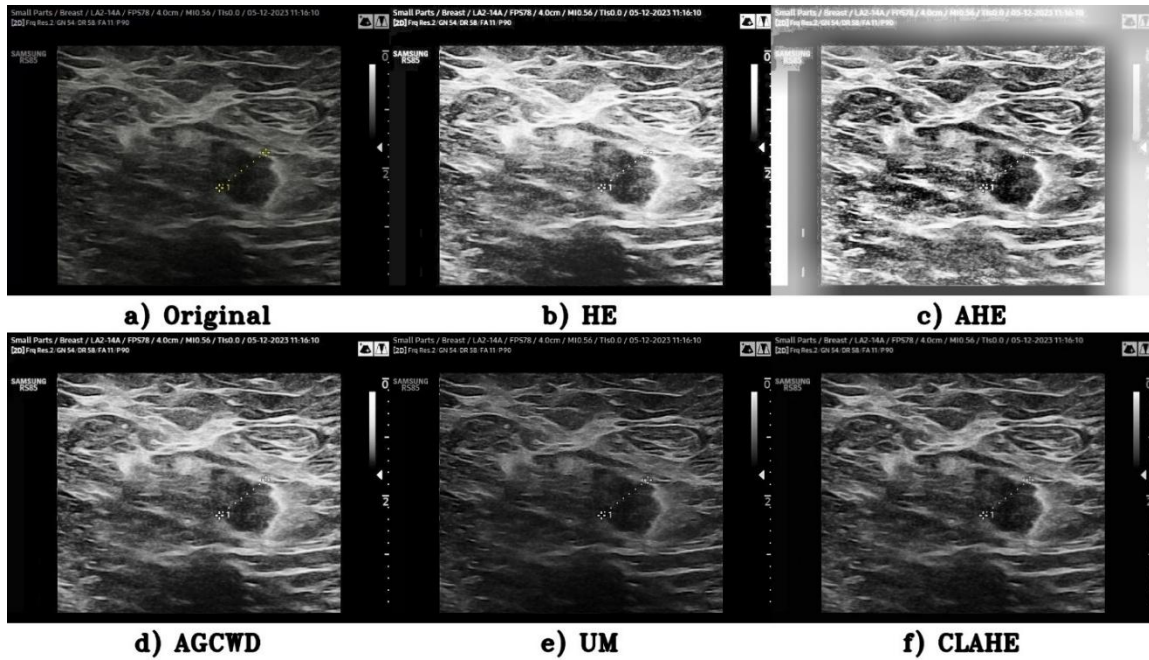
Comparison of Contrast Enhancement Techniques on a Benign Ultrasound Image
